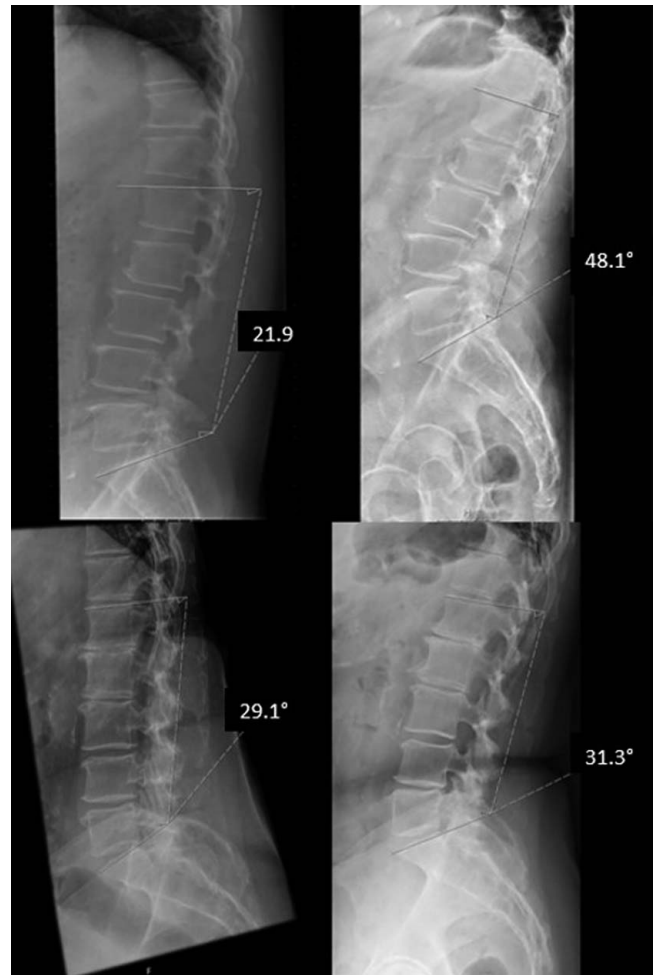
Preoperative (left) and two years postoperative (right) standing x-ray of a patient with a change in LL of > 10° (top) and a patient with a change of < 5° (bottom).
